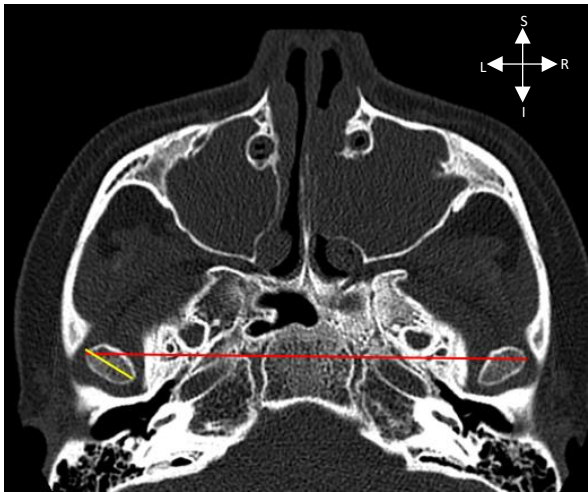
Horizontal CT of the mandibular region in the superior view displaying the mandibular width (red) and the mandible head width (yellow)
